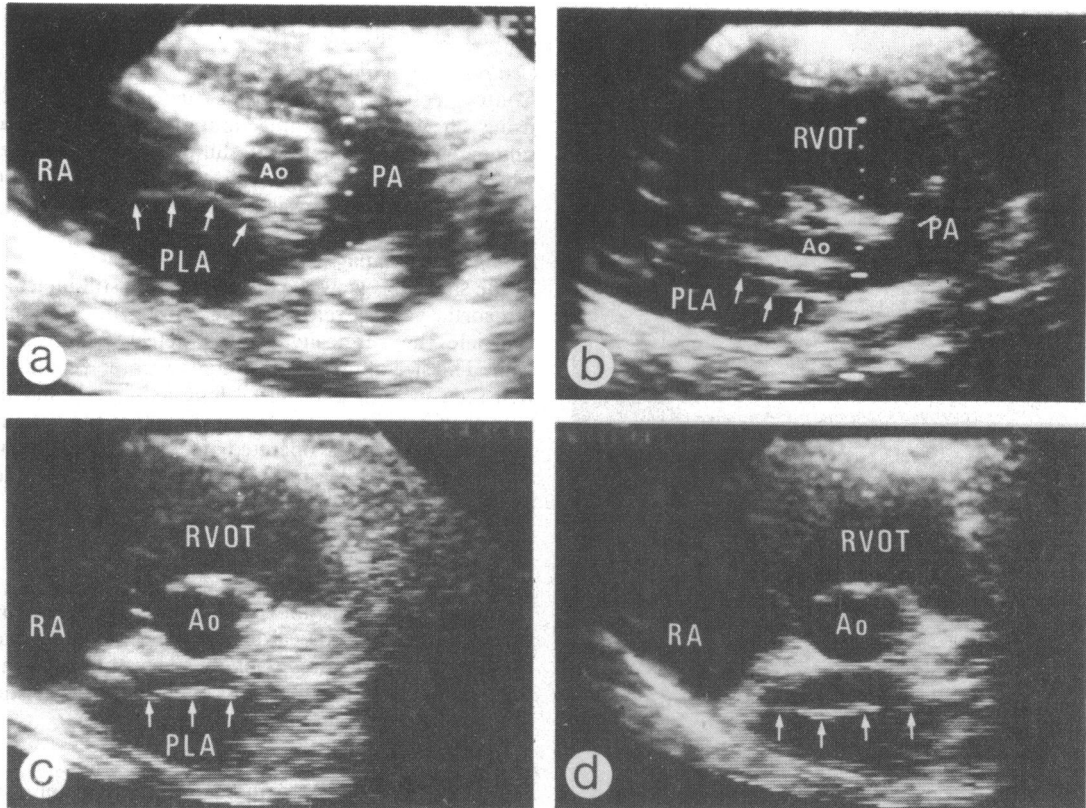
Cross sectional echocardiographic appearances in the parasternal short axis view. (a) Case 1: the abnormal membrane (small arrows) within the left atrium is quite close to the aortic root with the enlarged proximal left atrium posterior to it, but the small recess of the distal left atrium behind the aorta can still be seen at the aortic valve level. The aorta is small and the pulmonary artery enlarged. (b) Case 2: again the abnormal membrane (small arrows) anterior to the proximal left atrium is well seen at the aortic valve level. The aorta is small and the right ventricular outflow tract and the pulmonary artery notably enlarged. (c) and (d) (case 3) show the variation in the position of the abnormal membrane (small arrows) during the cardiac cycle. The aorta is of normal size. Ao, aorta; PA, pulmonary artery; RA, right atrium; PLA, proximal left atrium; RVOT, right ventricular outflow tract.
